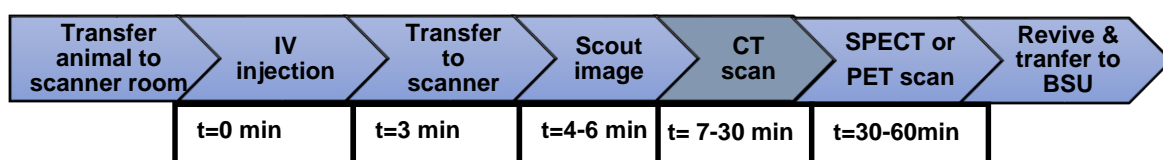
Steps involved in the longitudinal SPECT-CT and PET-CT imaging.
